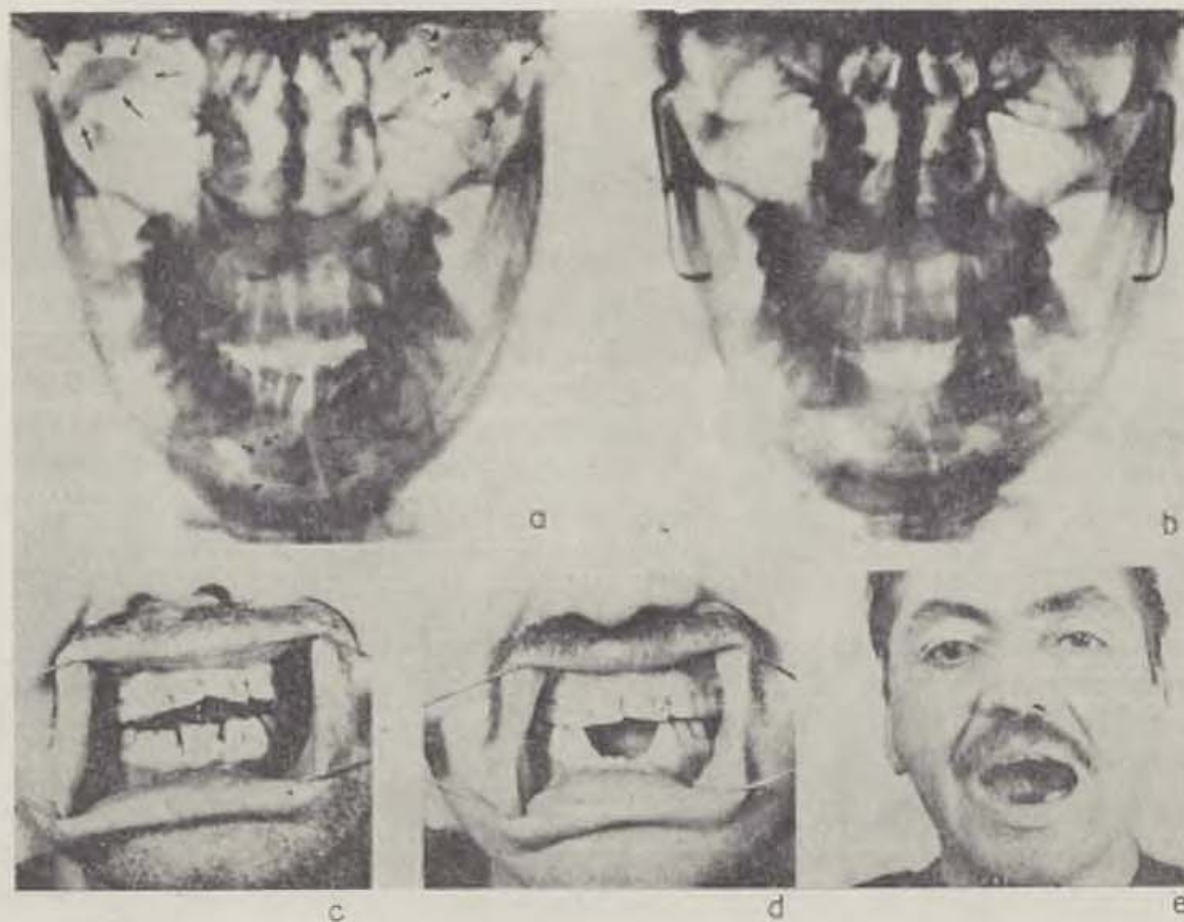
X-ray examination of mandibula, face and modes of bite of the patient B. Diagnosis: incorrectly healed bilateral fracture of mandibula affecting neck regions of both articular processes; open bite; dislocated $\overline{1} \mid 1$. a, b — roentgenograms of mandibula taken before treatment and after the operation (the dislocated articular heads are pointed out by arrows), c — mode of bite before treatment of the patient, d, e — mode of bite and patient's face after the treatment
